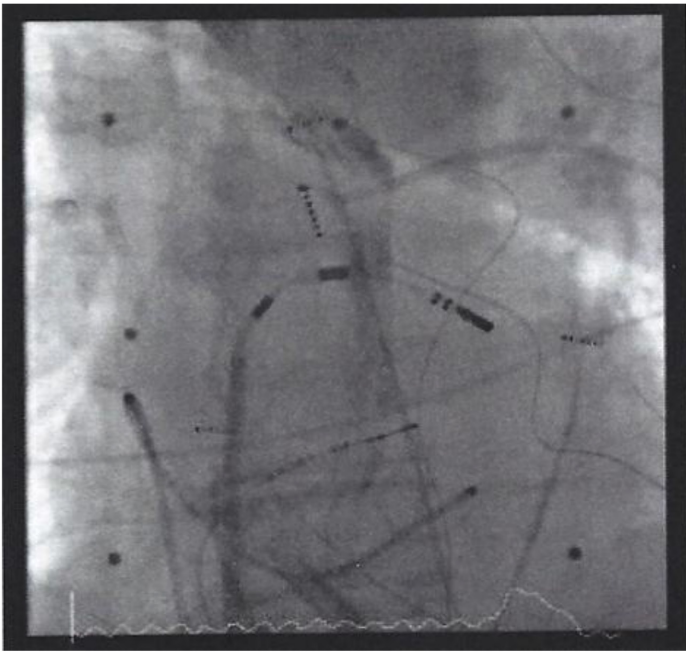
X-ray thorax: RMT ablation catheter in the LA
